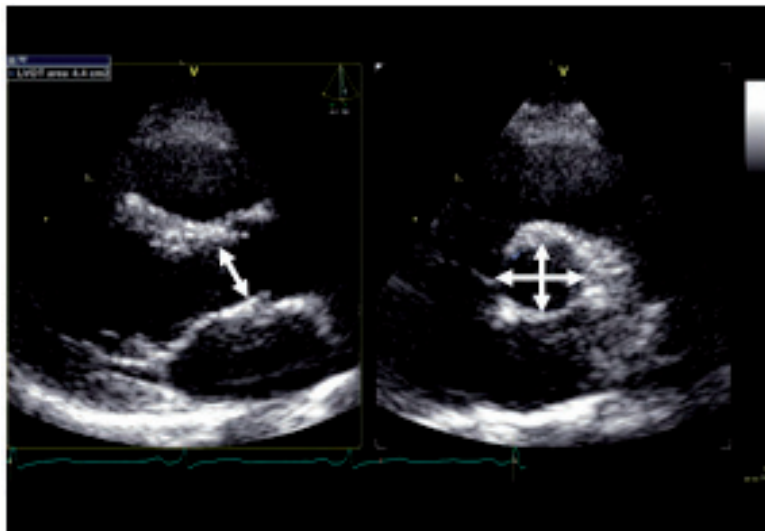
Simultaneous visualization of left ventricular outflow tract in parasternal long-axis (*left*) and in short-axis (*right*) using the biplane technique.
